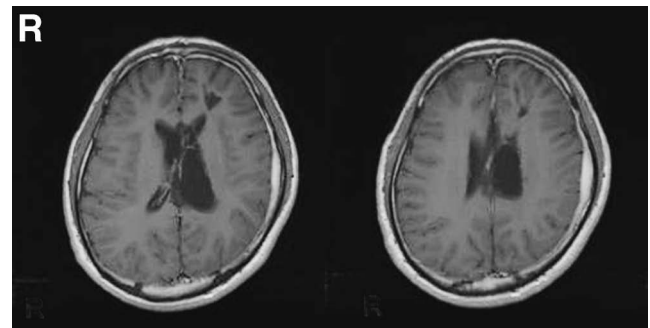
T₁-weighted magnetic resonance images with contrast medium obtained 4 months after surgery demonstrating no evidence of a recurrent tumor.
